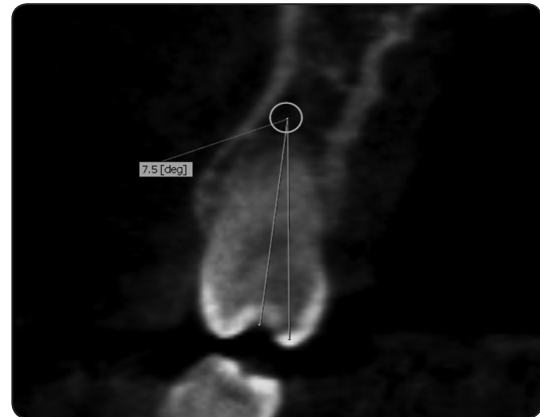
Coronal CBCT image showing the measuring of tipping angle of the right second premolar.
